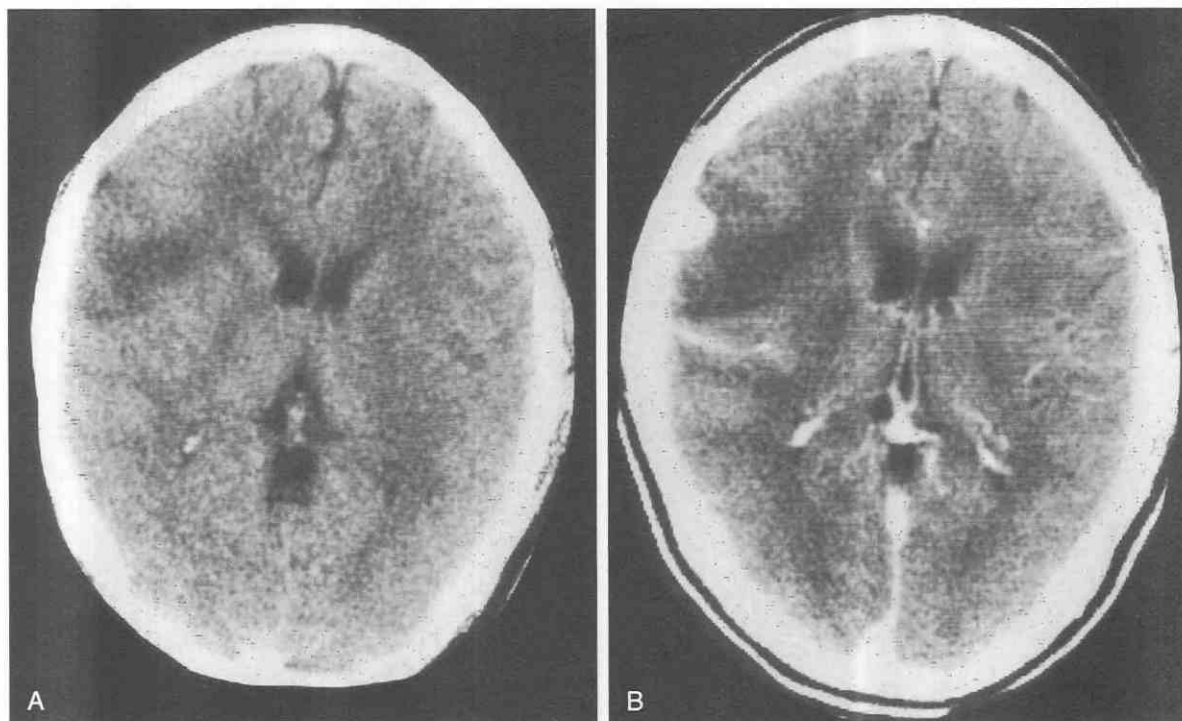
Tuberculoma. *A*, Noncontrast CT scan shows an isodense area with surrounding edema in the right frontal region. *B*, Contrast CT scan demonstrates nodular homogeneous enhancement.
